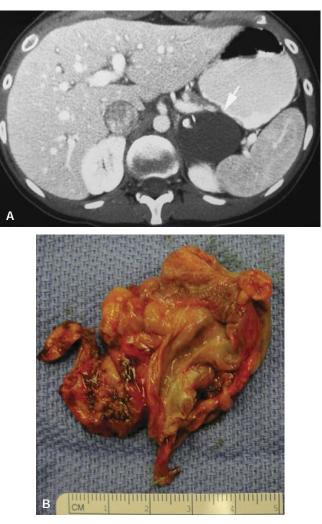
A 26-year-old woman had left upper quadrant pain. *A*, An abdominal computed tomographic scan showed a 6 cm \times 5 cm \times 4 cm left adrenal cyst (*white arrow*) with calcifications in the cystic wall. Biochemical workup showed no hyperfunction. She underwent a laparoscopic left adrenalectomy. *B*, Pathology showed a 6 cm endothelial cyst.
